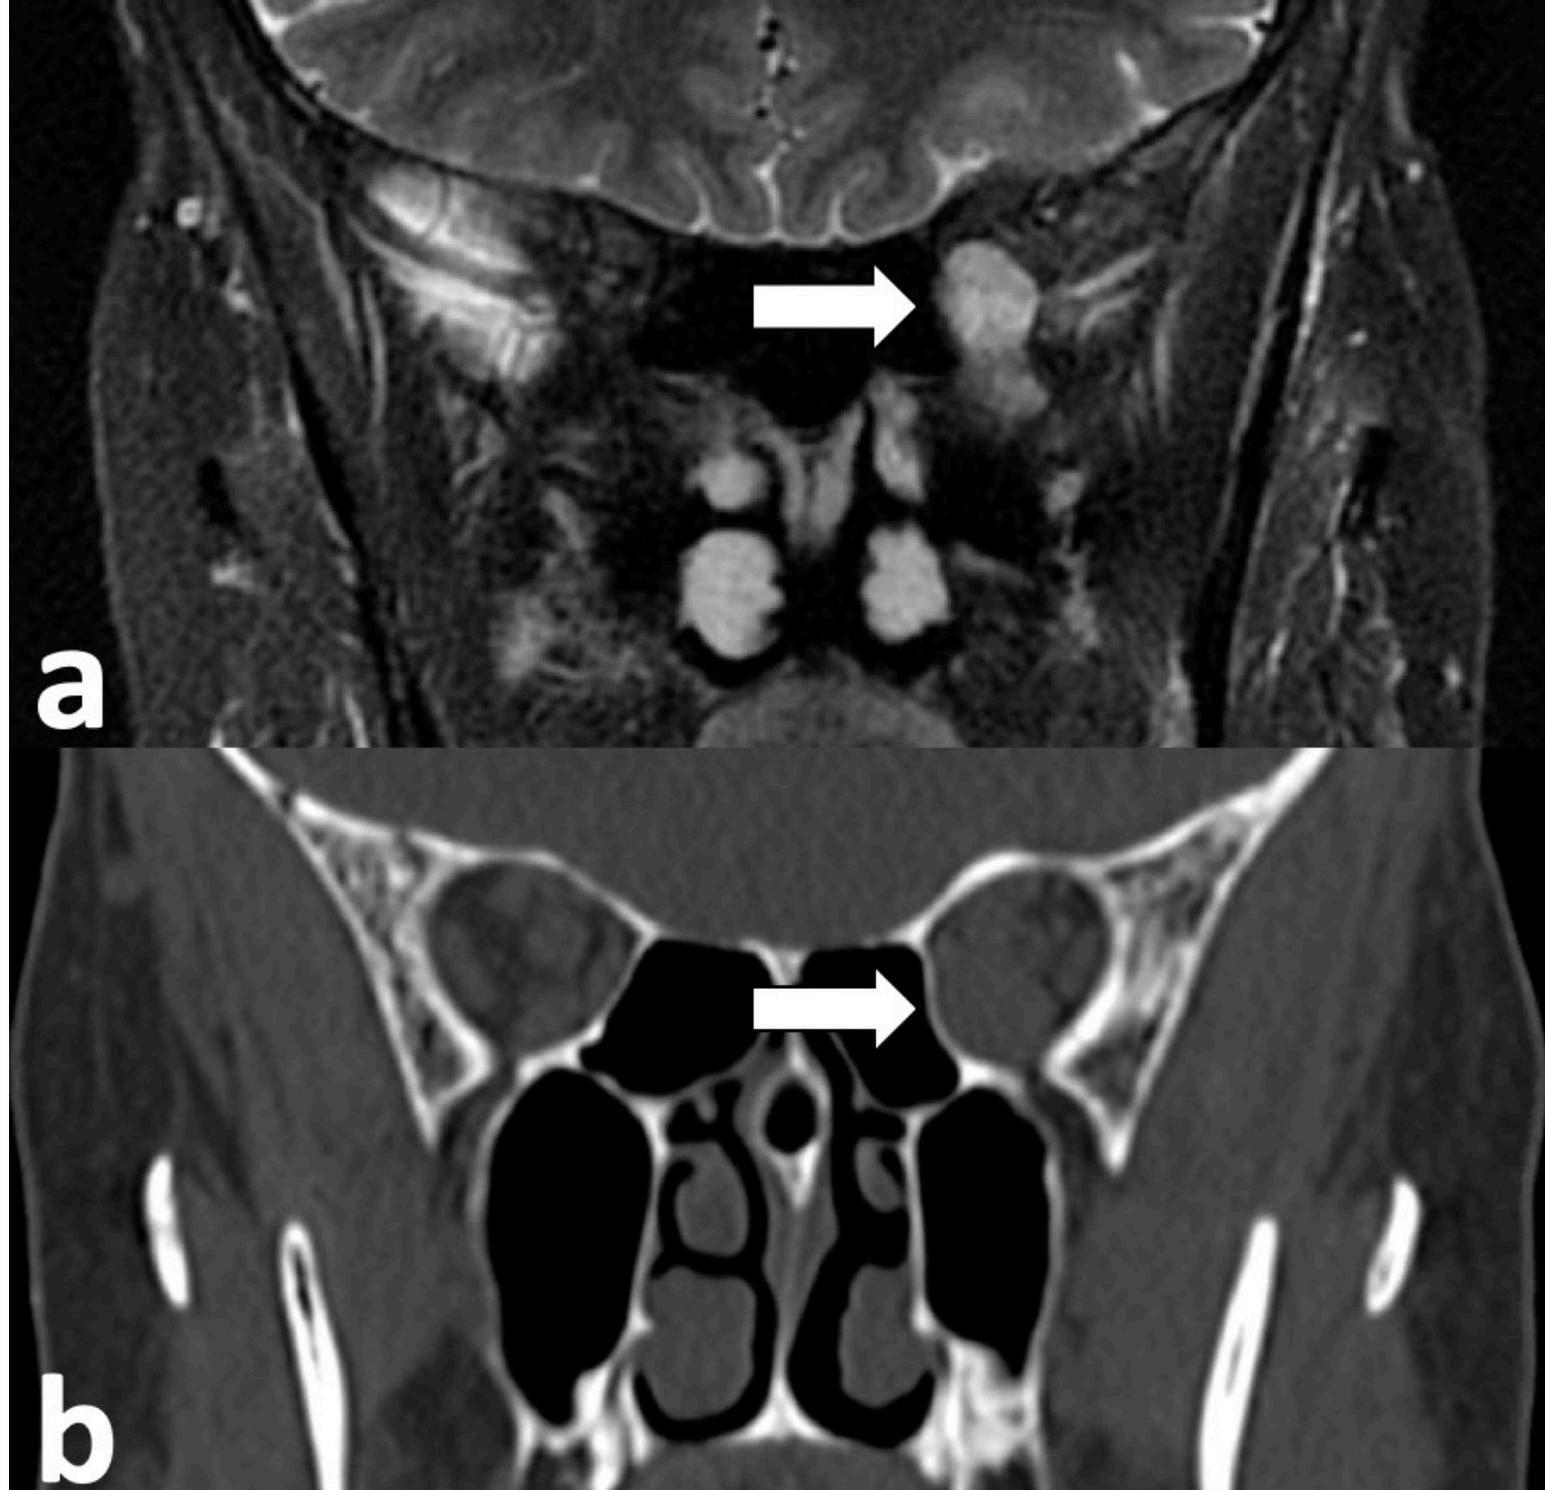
a) T2-weighted MRI with heterogeneously enhancing retrobulbar lesion on the patient's left with extension into the pterygopalatine fossa through the inferior orbital fissure (white arrow). b) Rounded, homogenous lesion between the medial and inferior rectus in the patient's left orbital apex (white arrow).
